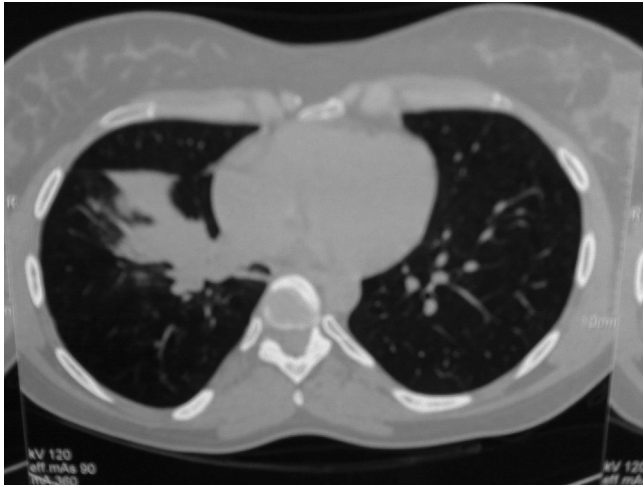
Chest CT scan showing peri-hilar localized pulmonary consolidation associated to partial right middle lobe collapse.
